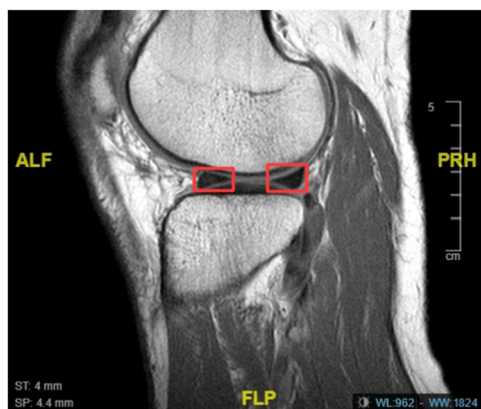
Image labelling for the lateral tibial slope measurement. The figure demonstrates the artificial intelligence model's autonomous detection of the meniscus at the centre of the lateral tibial plateau on sagittal magnetic resonance imaging images. ALF, anterior lateral femur; FLP, femorolateral posterior; PRH, posterior right horn.
